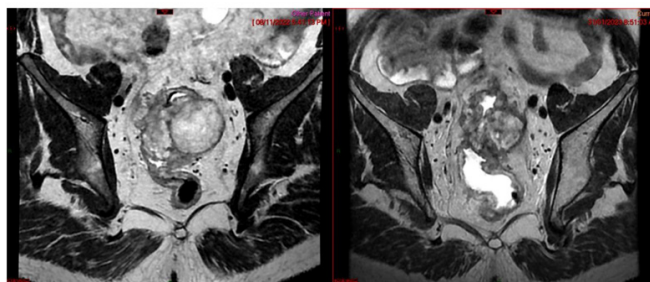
MRI at 3-month follow-up of patient Do Van M. (Case 2). Tumor size reduction after the first chemotherapy course. MRI: tumor regression grade 3 (moderate).
